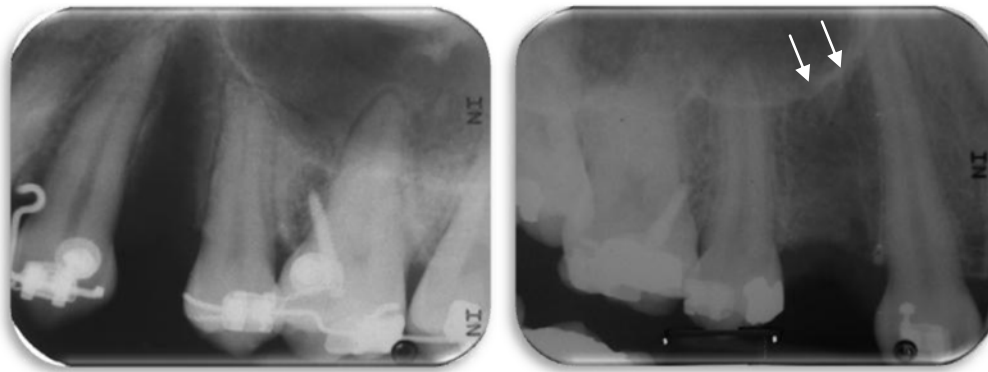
Post-operative periapical radiographs indicate bone thickness and socket depth after the procedure. Left radiograph shows that the surgical criteria were met, while the right one was not because of maxillary sinus pneumatization (arrow).
